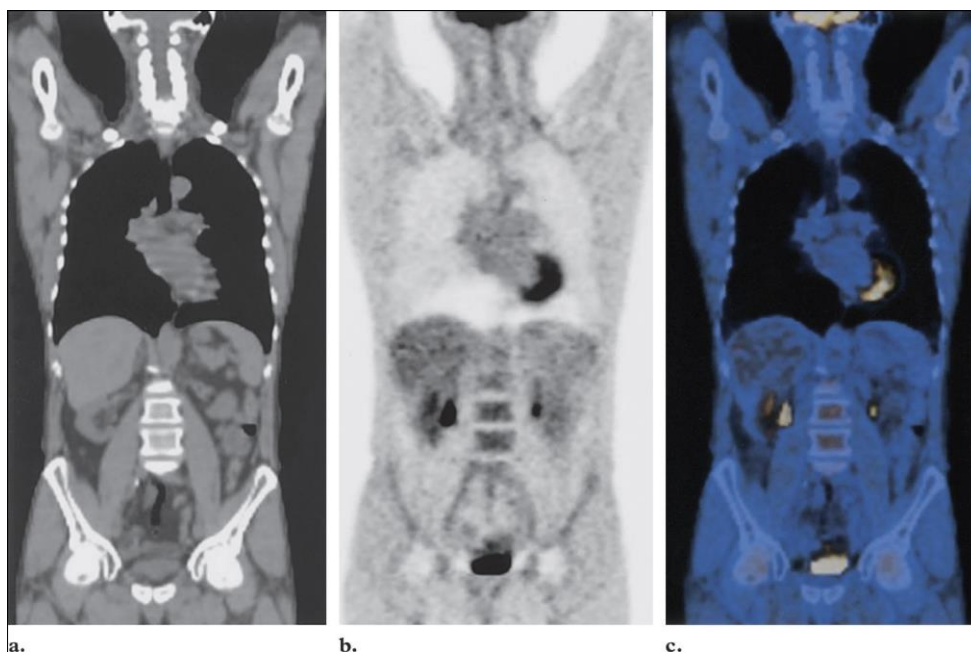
Normal distribution of FDG. Coronal CT (a), PET (b), and PET/CT fusion (c) images demonstrate the physiologic accumulation of FDG in the cerebral-cerebellar cortex at the base of the skull and in the myocardium, liver, kidneys, renal pelvis, bone marrow, and urinary bladder. Note also the minimal uptake in the mediastinum and bilaterally in the lower cervical and psoas muscles (*Quoted from Kostakoglu et al., 2003*).
